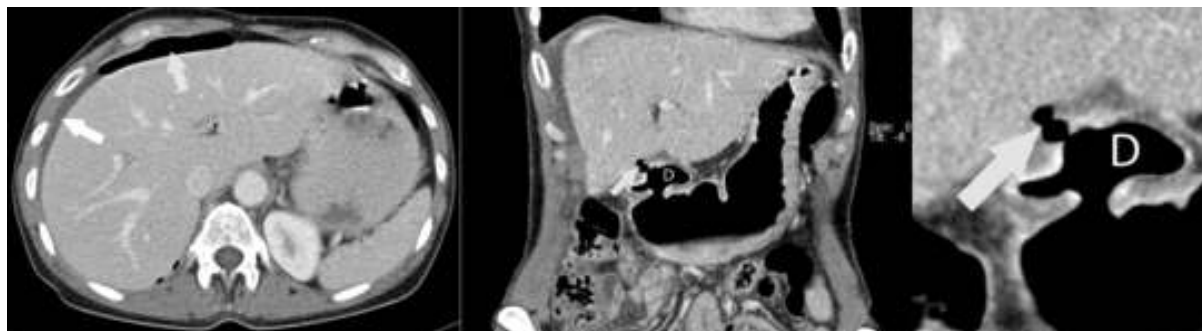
Perforated duodenal ulcer in computed tomography scan
